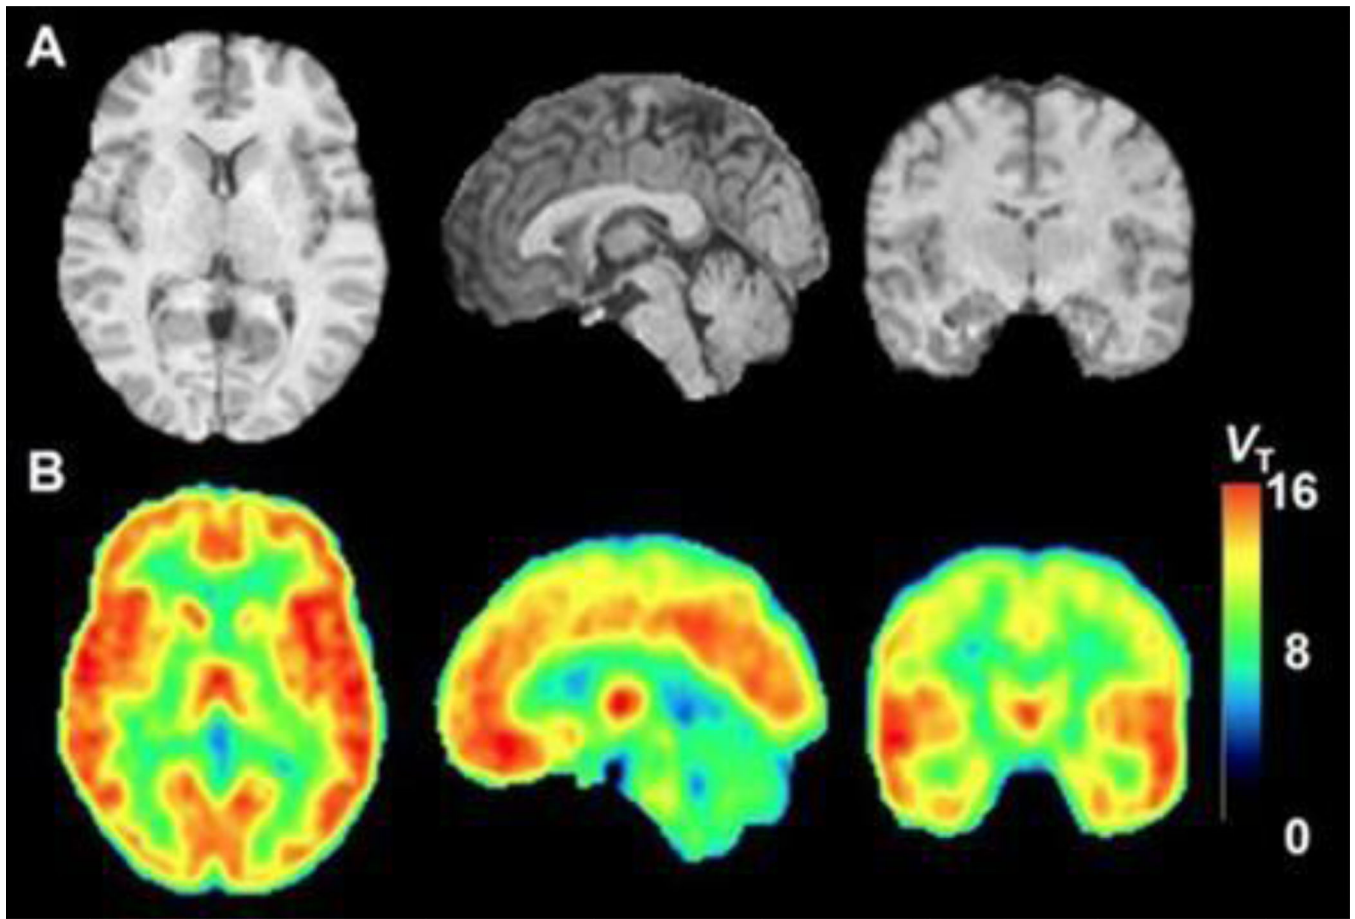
PET and MRI images of mGluR5 PET ligand [ $^{18}\text{F}$ ] SP203, showing raw and MRI fused receptor distribution in a human volunteer. Courtesy of Dr Robert Innis, National Institutes of Health, National Institute of Mental Health
